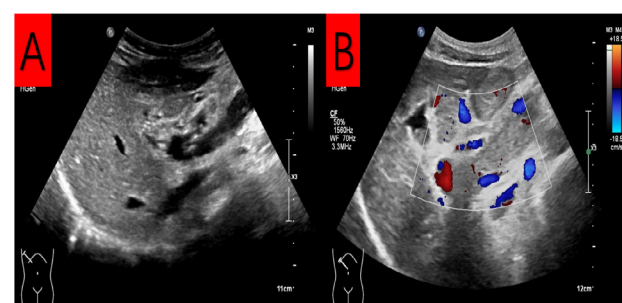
Follow-up abdominal vascular color Doppler ultrasound. A: The superior mesenteric vein thrombus disappeared; 2B: The old thrombus in the portal vein
